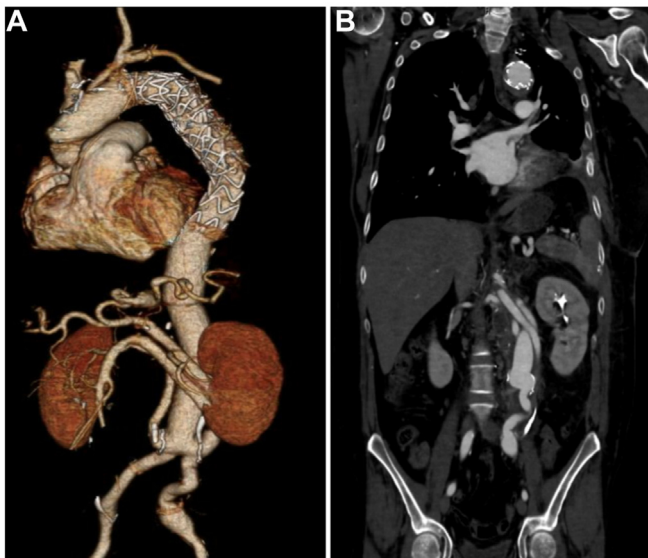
One-month postoperative computed tomography angiography (CTA). (A) Three-dimensional postprocessing images of a CTA demonstrating the complete aortic repair (B) Coronal CTA image demonstrating patent visceral vessels.
